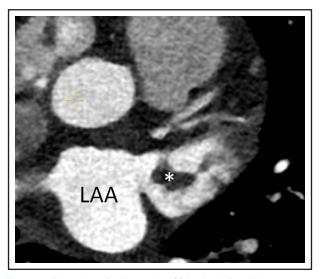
Example of a thrombus (*) in the left atrial appendage (LAA) on cardiac computed tomography.
